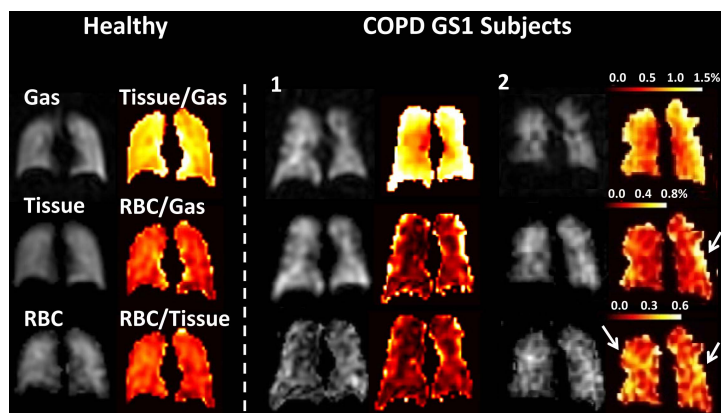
Representative Xe129 dissolved-phase MR images and ratio maps from one healthy subject and two COPD GOLD stage (GS) 1 subjects. As compared with the healthy subject (whole-lung mean tissue-to-gas ratio: 1.29%, RBC-to-gas ratio: 0.36%, RBC-to-tissue ratio: 0.28), COPD subject 1 had normal to slightly elevated tissue-to-gas ratios (mean 1.33%), and lower RBC-to-tissue and RBC-to-gas ratios (mean 0.14 and 0.18%), while COPD subject 2 had lower tissue-to-gas ratios (mean 0.90%), but regionally elevated RBC-to-gas and RBC-to-tissue ratios (arrows, whole-lung mean 0.28% and 0.31, in the normal range).
